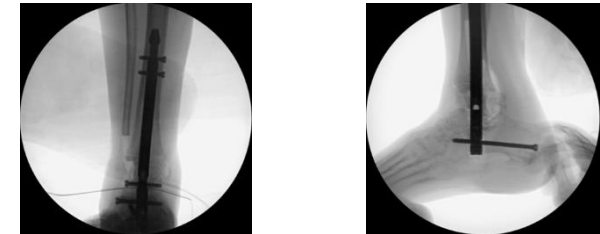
Final radiographs showing consolidation (A. AP Ankle, B. Lateral view) of IM nail with fibular pillar grafts.
